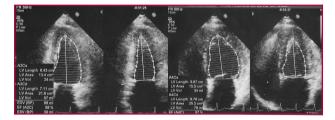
Post-ablation echocardiogram.
